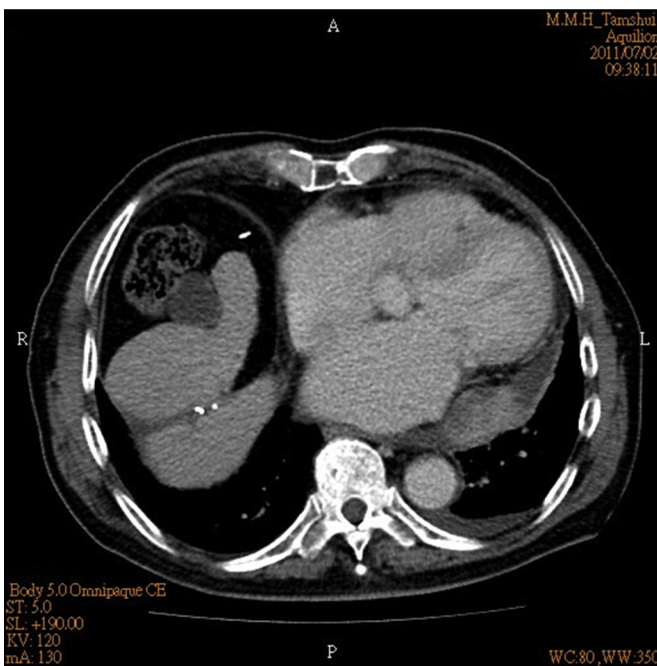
A computed tomography scan reveals a 4.7 cm × 2.5 cm soft tissue nodule present in the pericardial space along the left atrioventricular groove with mild pericardial effusion.
